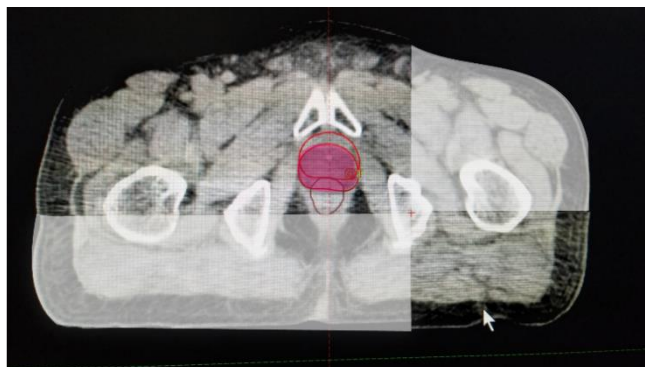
The rectum volume on high dose region from daily CBCT
